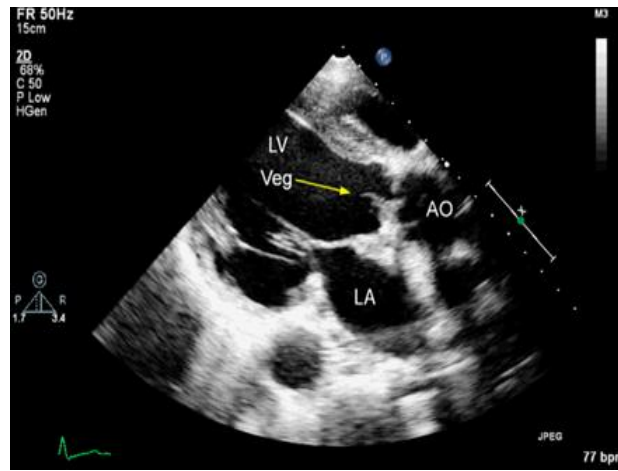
Transthoracic echocardiogram in longitudinal parasternal section showing vegetation (Veg) adhered to the aortic biological prosthesis projecting to the left ventricle (LV) exit pathway. AO: aorta; LA: left atrium.
